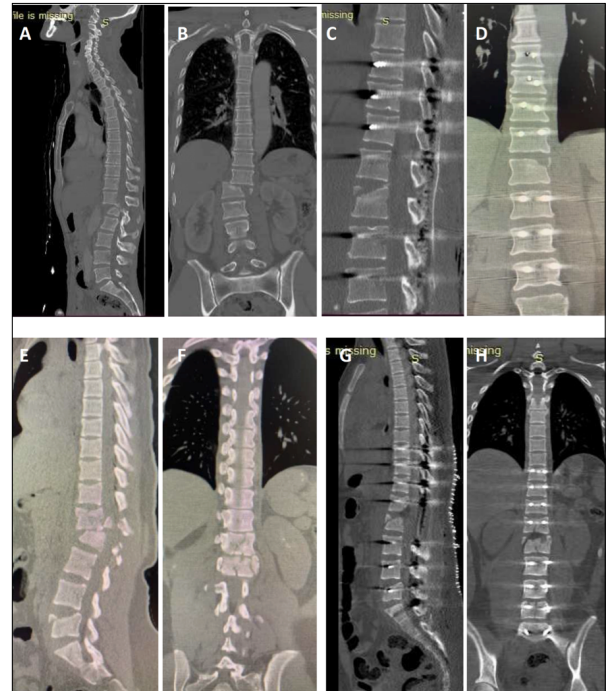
(a) Preoperative sagittal thoracolumbar CT image of Case 3, (b) Preoperative coronal thoracolumbar CT image of Case 3, (c) Postoperative sagittal thoracolumbar CT image of Case 3, (d) Postoperative coronal thoracolumbar CT image of Case 3, (e) Preoperative sagittal thoracolumbar CT image of Case 4, (f) Preoperative coronal thoracolumbar CT image of Case 4, (g) Postoperative sagittal thoracolumbar CT image of Case 4, (h) Postoperative coronal thoracolumbar CT image of Case 4.
